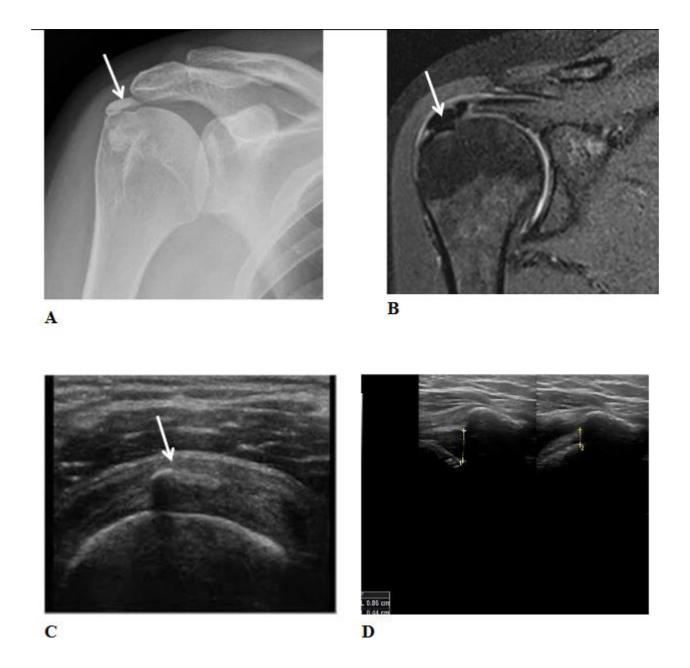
A Digital Radiography revealed dense calcific focus at region of supraspinatous tendon (arrow) .B MRI coronal STIR WI shows abnormal intrinsic (dark) low signal intensity near the humeral insertion of the supraspinatus tendon (arrow).C Static US shows swollen supraspinatus tendon with ill- defined areas of reduced echogensity and hyperechoic foci within its fibers denoting calcific tendinopathy (arrow).Ddynamic US shows relative narrowing of the sub acromial tunnel that was increased in stress position.
